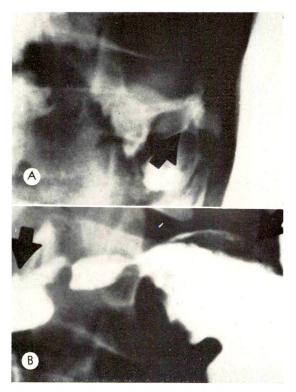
(A) Arrow points to duodenal ulcer with the antrum ascending to the duodenum. Roentgenogram was made on February 29, 1961. (B) On March 30, 1961 the duodenal ulcer is still visualized (arrow) but now the antrum has been markedly elevated and fixed with "trapped air" and descends to the duodenum.
